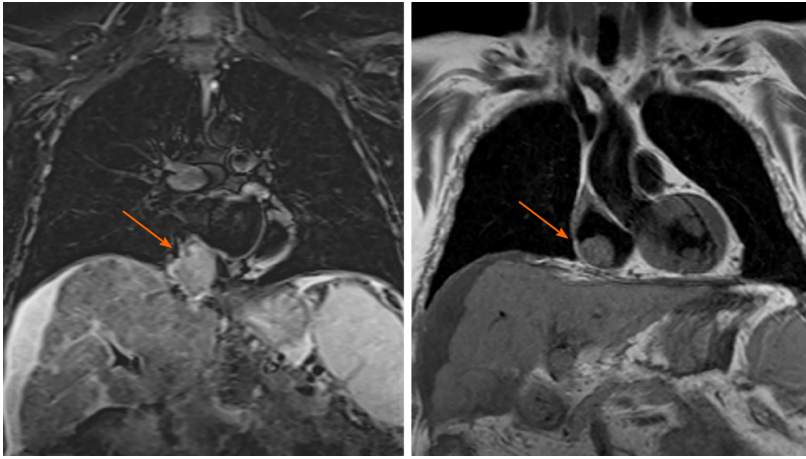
Magnetic resonance imaging coronal view of a polylobulated mass of 59 mm × 51 mm × 52 mm inside the right atrium (right arrow), which extends from the liver through the inferior vena cava (left arrow) to the inside of the right atrium occupying its lower-posterior wall. These findings suggest as the first diagnostic possibility: A tumor thrombus of an advanced infiltrating hepatocellular carcinoma. Volumes and biventricular function within physiological parameters.
